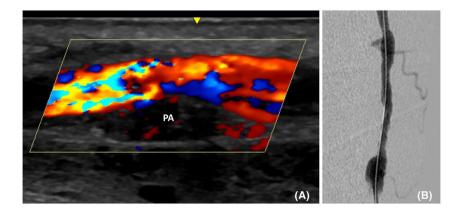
(A) Ultrasound image confirming complete thrombosis of the pseudoaneurysm with preserved flow in the lumen of the arteriovenous fistula. (B) Final angiography showing total exclusion of the pseudoaneurysm
